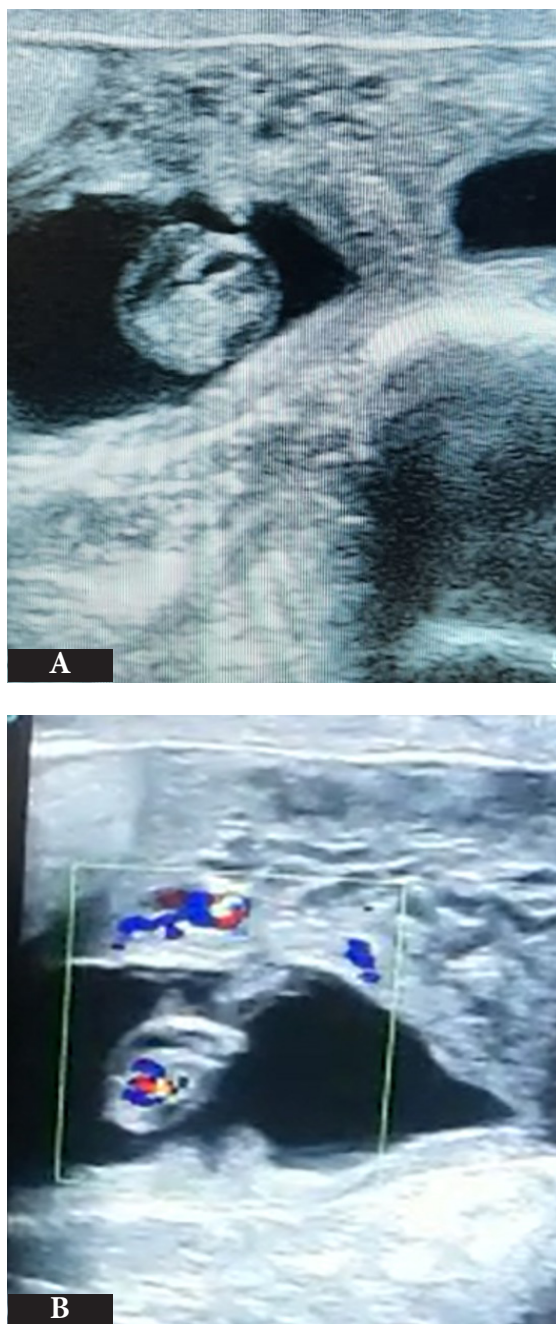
Ultrasonographic evidence of accumulated genital secretions
